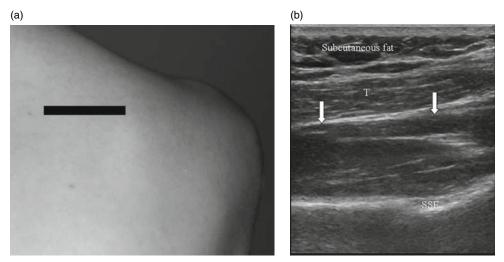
Supraspinatus muscle (arrows): (a) transducer position and (b) corresponding longitudinal ultrasound image. SSF, suprascapular fossa; T, trapezius.
